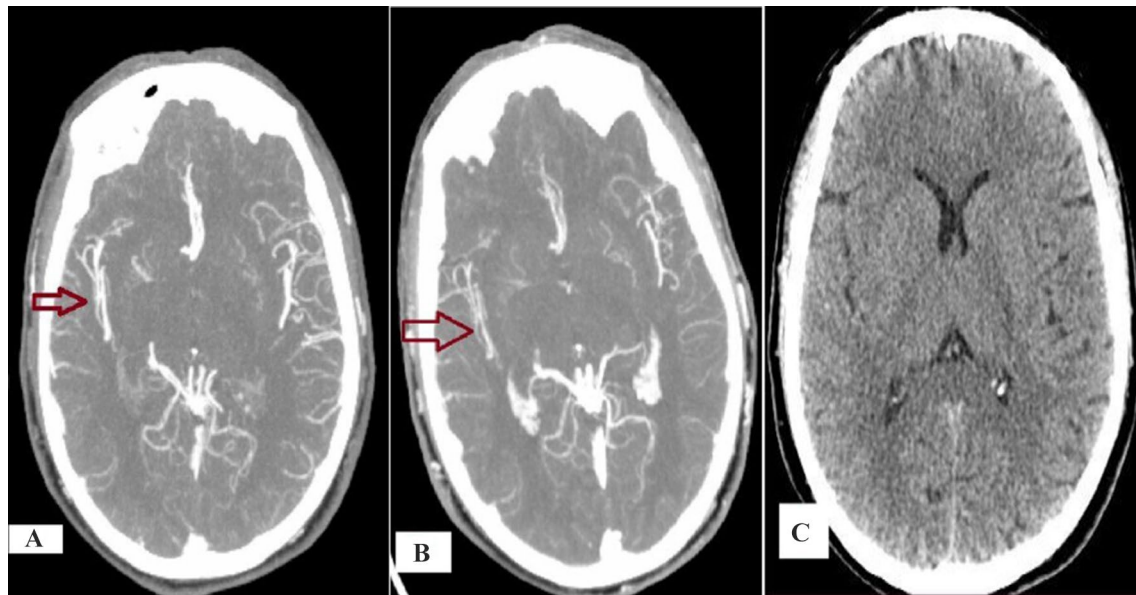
Patient with pre-tPA NIHSS = 5. A Good collaterals before rtPA “Mittef 3”. B Good collaterals after rtPA. C Better ASPECTS “10”. mRS = 0
